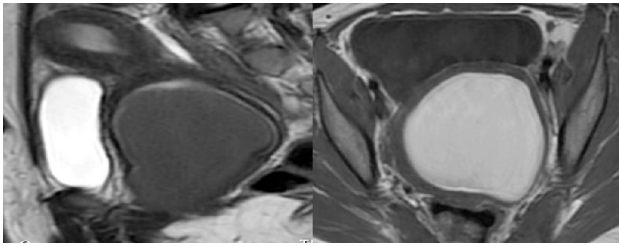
MRI T2 weighted Sagittal and T1 weighted Coronal Images: Distension of vaginal cavity by blood is noted (Low signal intensity on T2 and High signal intensity on T1 weighted images). Findings represent Hematocolpos.
